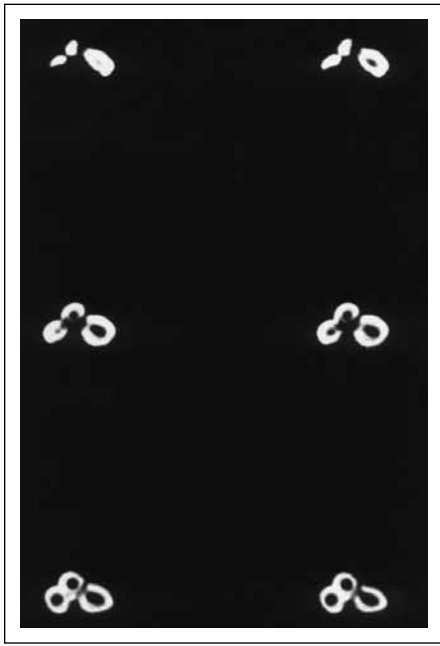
Series of CT images shows horizontal tomographic sections of the triple tooth crown of case no. 2. At the occlusal level three separate crowns are seen. At the mid-crown level the distal and labial crowns have become joined. The three separate pulp chambers are not joined anywhere in the coronal portion. At the CLI level the three crowns have become joined.
